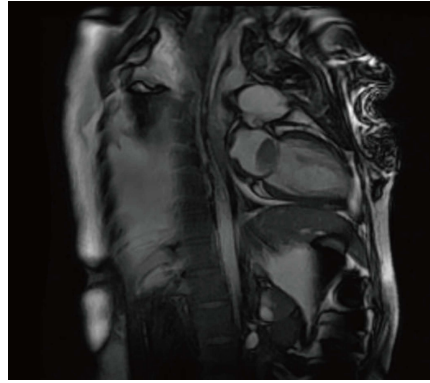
Cardiac magnetic resonance imaging showing a large mass in the left atrium.
